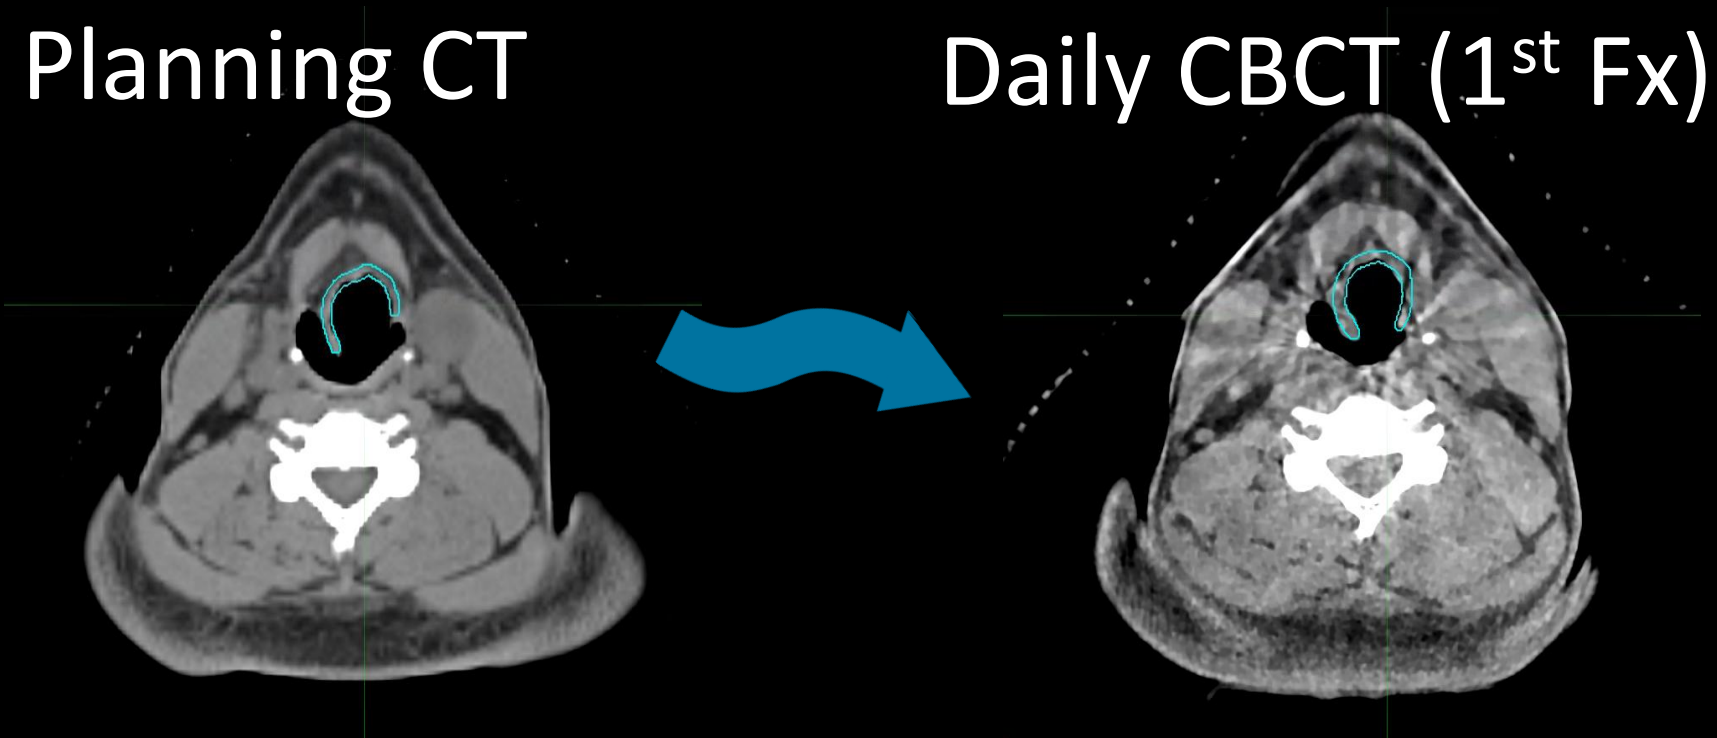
Planning CT (left) and daily CBCT from 1st fraction of the RT (right). The supraglottic volume (in turquoise) was transferred from the planning CT to the 1st treatment day CBCT through deformable registration.
